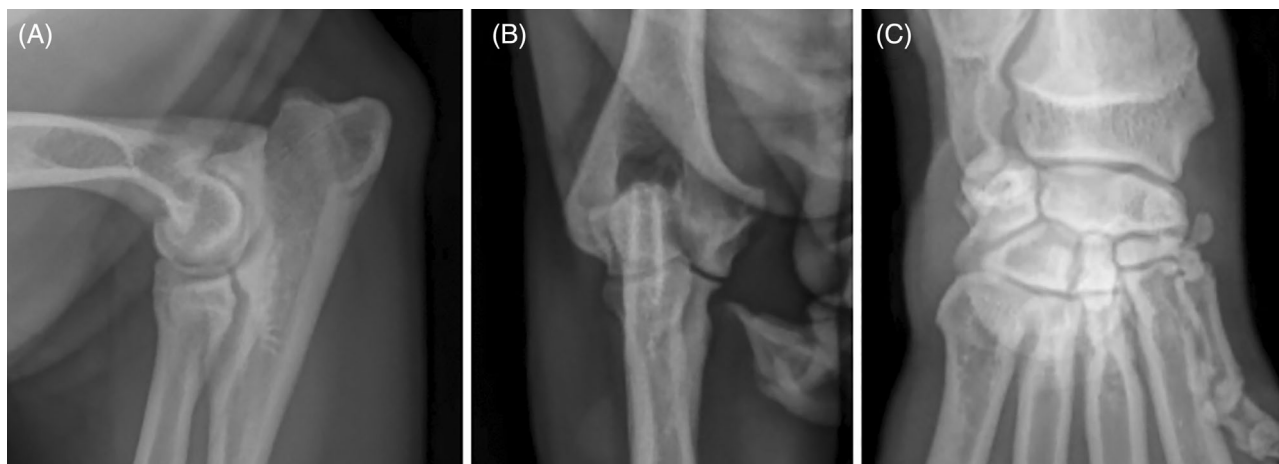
Mediolateral (A) and craniocaudal (B) radiographic projections of the right elbow. There is mild to moderate sclerosis of the ulnar trochlear notch, extending to the region of the medial and lateral coronoid processes, without evidence of fragmentation. Dorsopalmar radiographic projection of the right carpus (C) showing a bipartite second carpal bone with mild enthesophyte formation along the lateral margin of the ulnar carpal bone.
